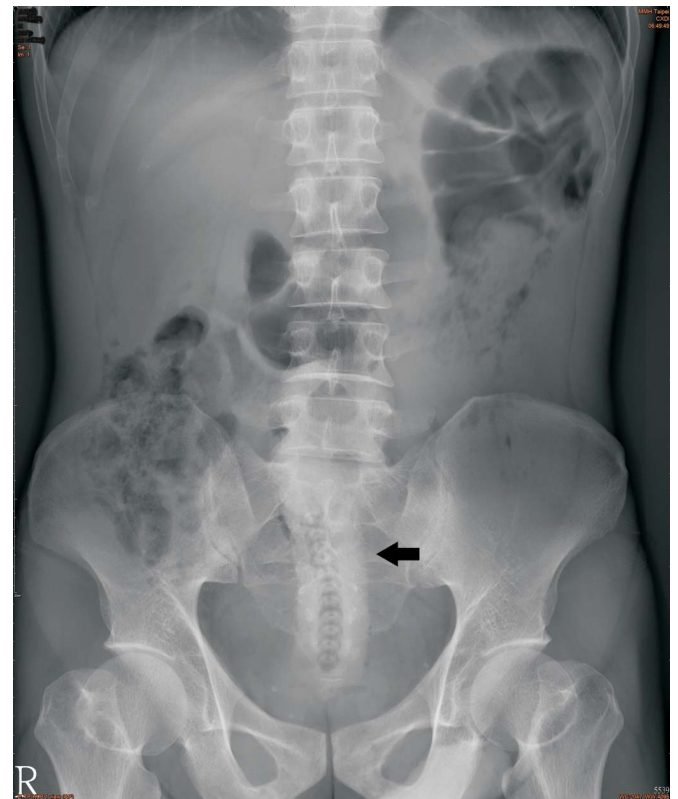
Kidney, ureter and bladder x-ray demonstrated a 12.4 cm radioopaque retained rectal foreign body superimposed onto pelvic cavity.
